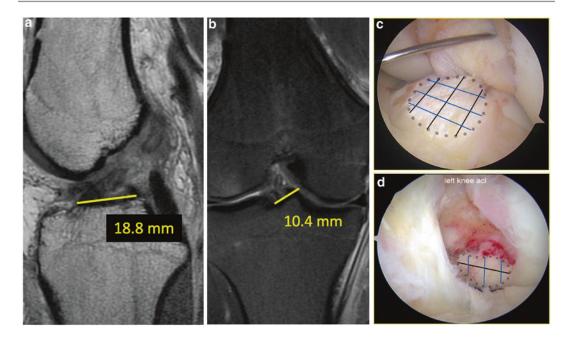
Determination of native tibial insertion site dimensions of ACL, as performed for individualized anatomic ACLR. Measurement of a sagittal and b coronal ACL length at tibial insertion site on MRI. Intraoperative measurement of c tibial and d femoral insertion sites
